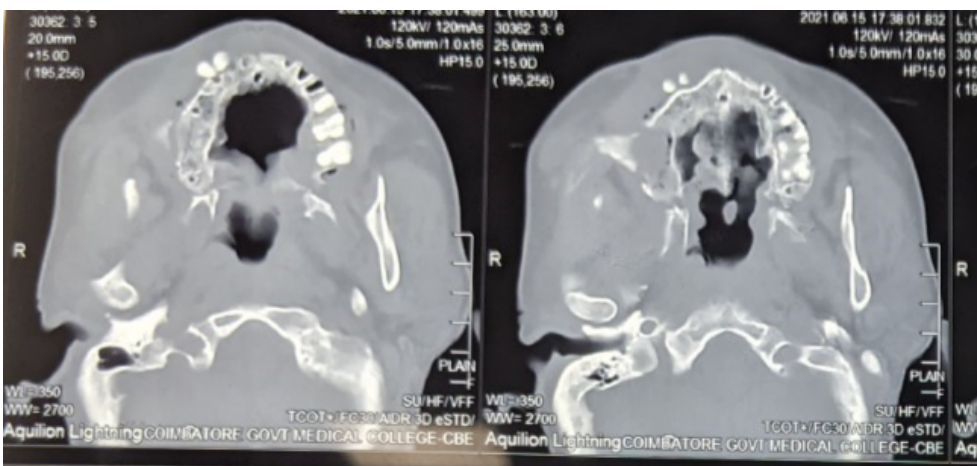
c: Computed Tomography images showing ROCM involvement
